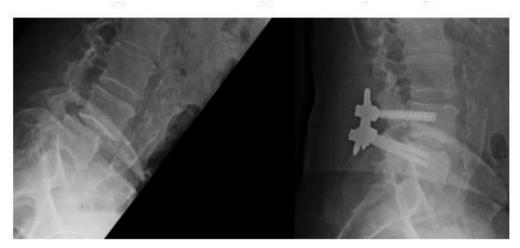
Pre- (left) and postoperative (right radiographs demonstrating instrumented correction of spondylolithesis
